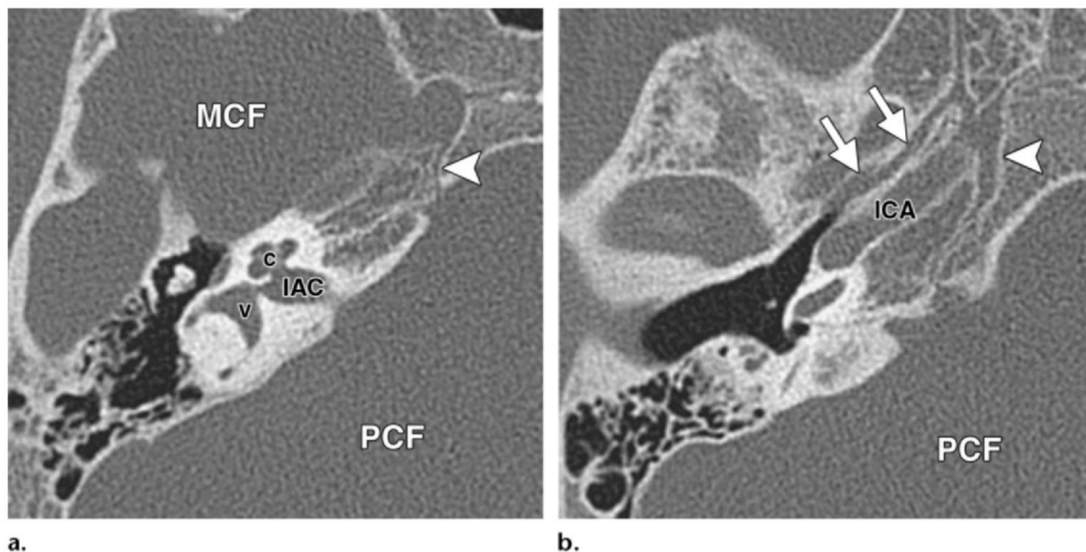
Normal petrous apex at CT. Axial CT images of the right temporal bone, obtained at the level of the IAC (a) and slightly more inferiorly at the level of the horizontal petrous carotid canal (b), show the normal petrous apex, which is bounded anteriorly by the petrosphenoidal fissure (arrows in b) and middle cranial fossa (*MCF* in a), posteriorly by the posterior cranial fossa (*PCF*), and medially by the petroclival fissure (arrowhead). The IAC divides the petrous apex into an anterior portion that usually contains marrow and a denser posterior portion that is derived from the otic capsule. *C* in a = cochlea, *ICA* in b = ICA canal, *V* in a = vestibule.
